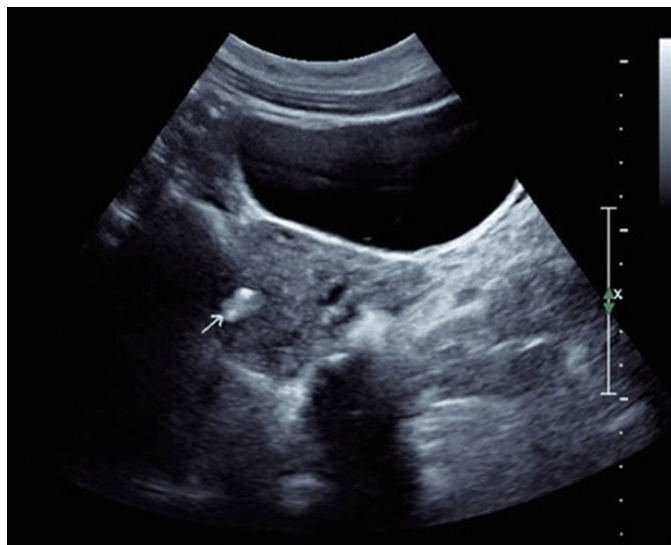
Trans-vaginal ultrasound showed a single echogenic focus within the endometrium of the superior left uterine fundus (white arrow). It had a lobulated morphology and demonstrated faint posterior acoustic shadowing.
